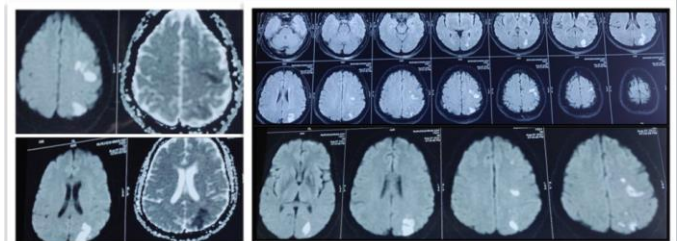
Showing T2 Flair, DWI And ADC Imaging Showing Hyperintensity In Left Inferior Frontal, Perisylvian And Posterior Watershed Area With Diffusion Restriction With Low ADC
